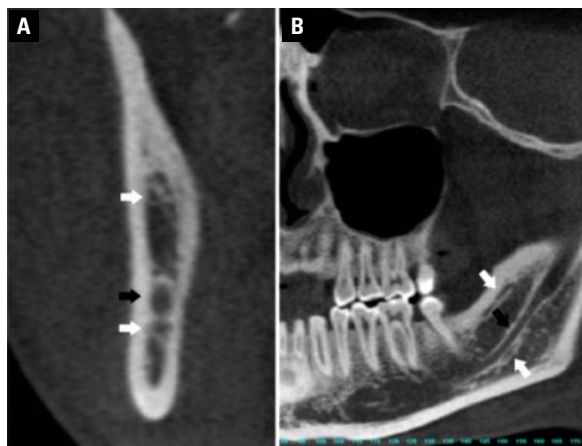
Trifid mandibular canal (white arrow); main mandibular canal (black arrow). Coronal view (A) and panoramic view (B) of cone-beam computed tomography image improved with SimPlant.
